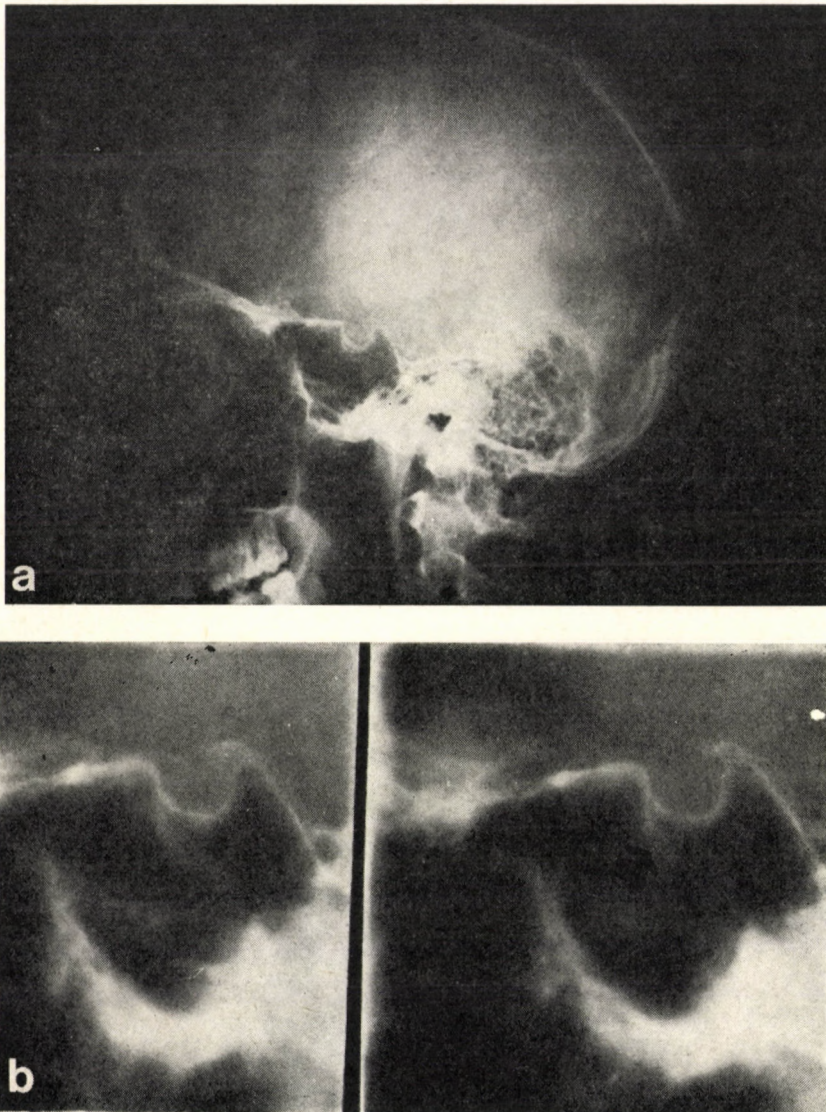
Lateral skull X-rays and sagittal tomogram of the sella of patient 3. *a* The lateral film of the sella shows no abnormality. *b* Localized bulging (arrow) of the sella floor is visible
